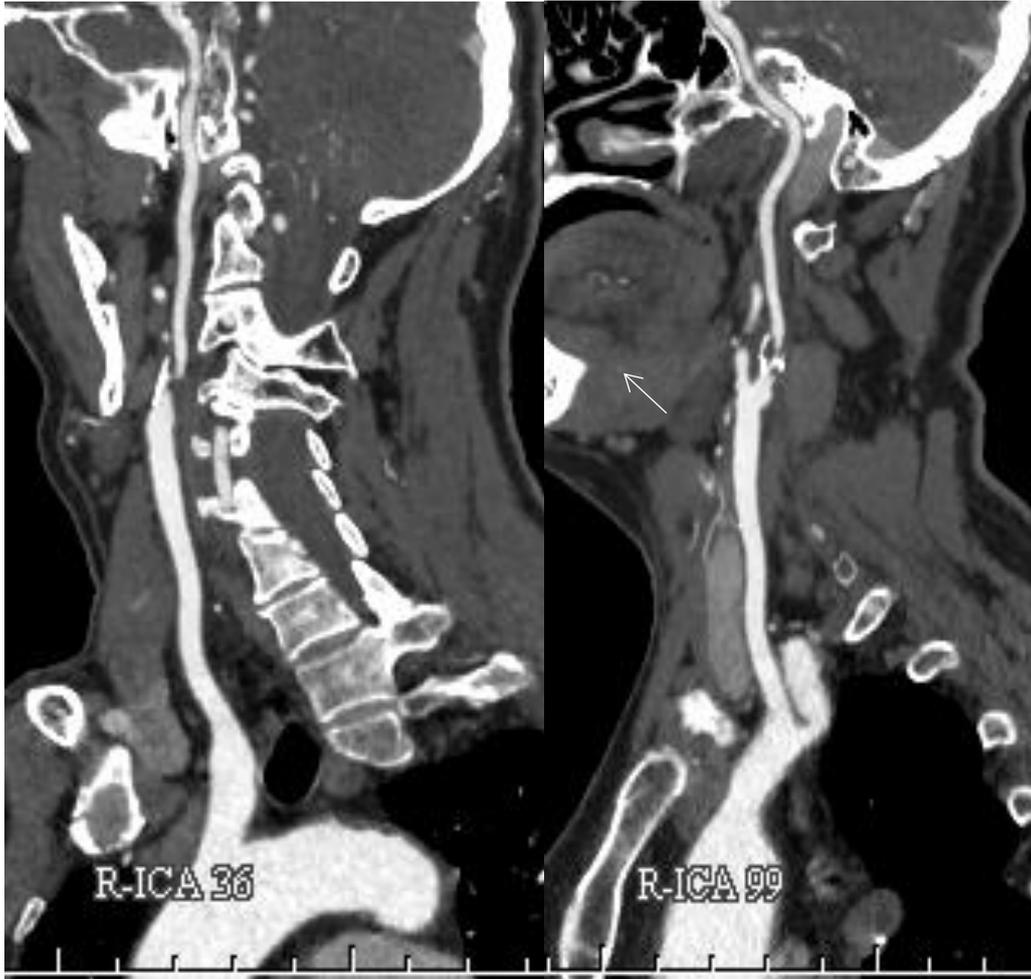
Right carotid CTA
